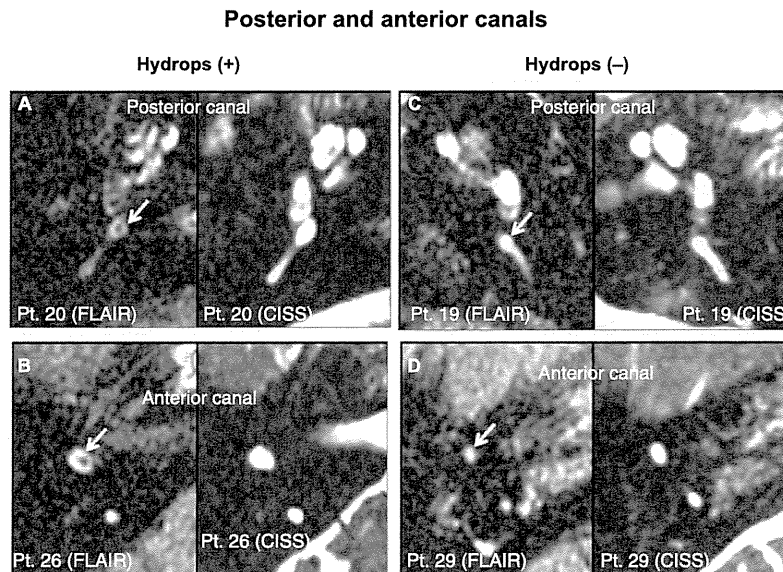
Hydrops-positive (A and B) and hydrops-negative (C and D) vertical canals in 2D-FLAIR and CISS images. (A and B) In 2D-FLAIR images, cross-sectional images showing an enlarged endolymphatic space of the posterior (A) and anterior (B) canals are seen as low or no signal intensity area (arrows) surrounded by perilymphatic spaces that are seen as high signal intensity area due to gadolinium enhancement. (C and D) In 2D-FLAIR images, no remarkable low signal intensity area was found in the posterior (C) and anterior (D) canals. CISS images in the same plane were helpful in identifying inner ear structures. The numbers in the figures indicate the patient ID numbers.
